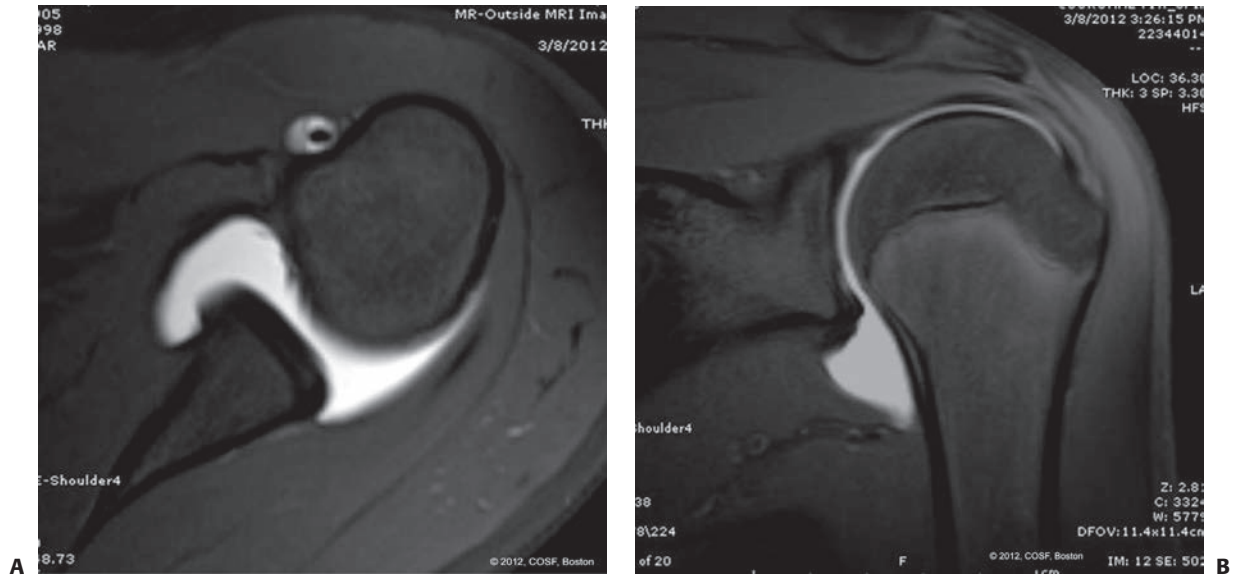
MRI arthrogram of the left shoulder in a 14-year-old female with multidirectional instability. Axial (A) and coronal (B) images depict an intact labrum with a patulous capsule.
